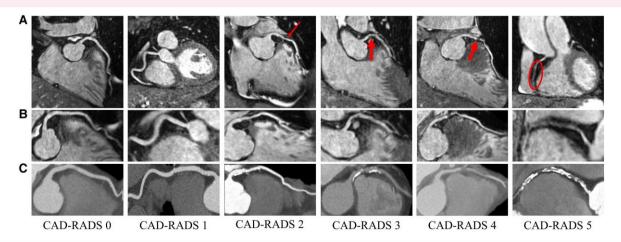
Examples of Coronary Magnetic Resonance Angiography (CMRA) in comparison with Coronary Computed Tomography Angiography (CCTA) at different CAD-RADS classifications. (A) CMRA images of the whole heart; red arrows show focal lesions. (B) A zoomed CMRA image of the coronary artery. (C) CCTA images of the same coronary artery. The LAD is visualized for CAD-RADS 0, 2, 3, and 4, whilst the right coronary artery is shown for CAD-RADS 1 and 5. CAD-RADS, Coronary Artery Disease-Reporting and Data System.
